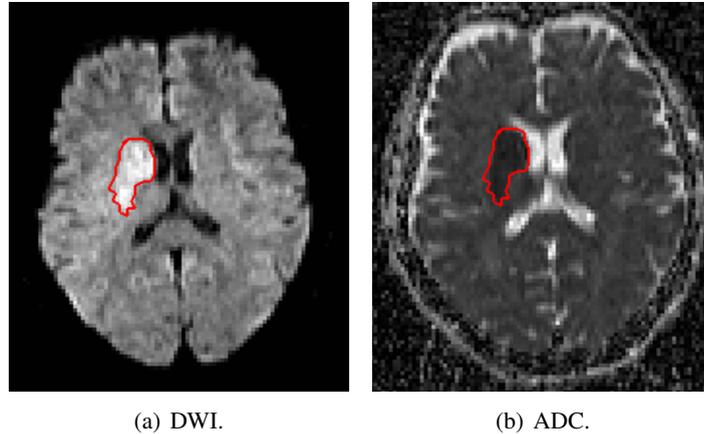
DWI(a) and ADC parameters(b) showing core of infarct in acute stroke (Hour 0).
